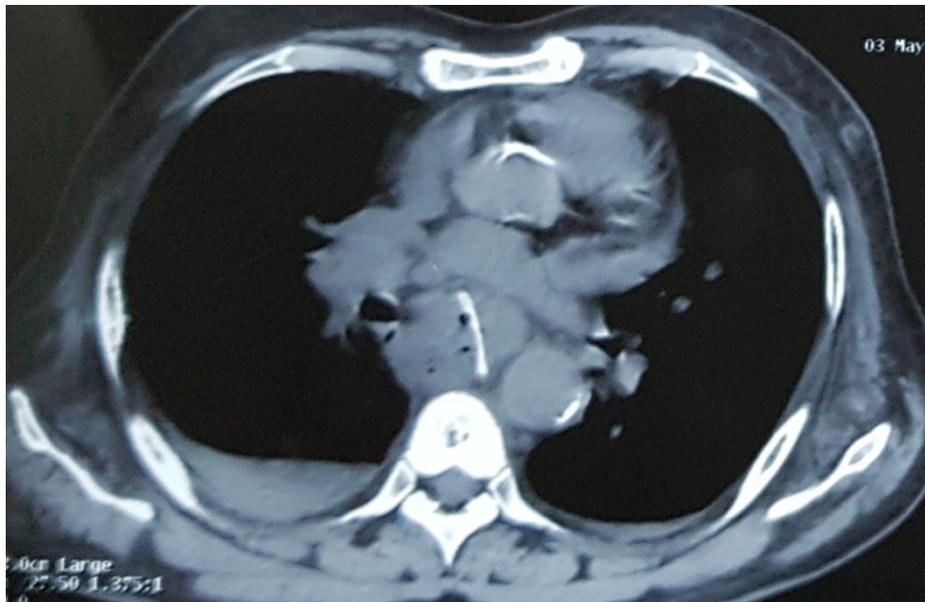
HRCT chest showing esophageal foreign body perforation with pneumomediastinum and bilateral pleural effusion
